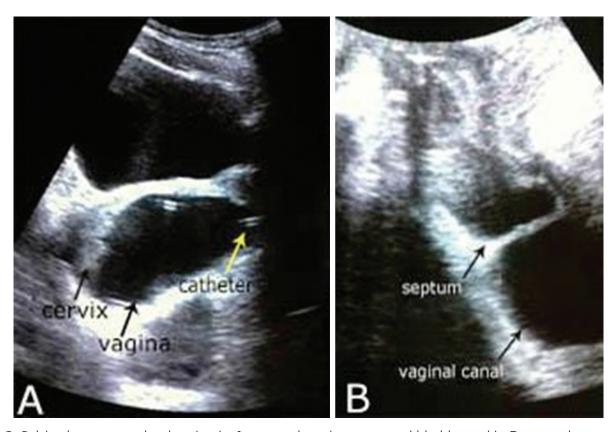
Pelvic ultrasonography showing in A - normal cervix, uterus and bladder and in B - note the presence of an incomplete vaginal septum.
